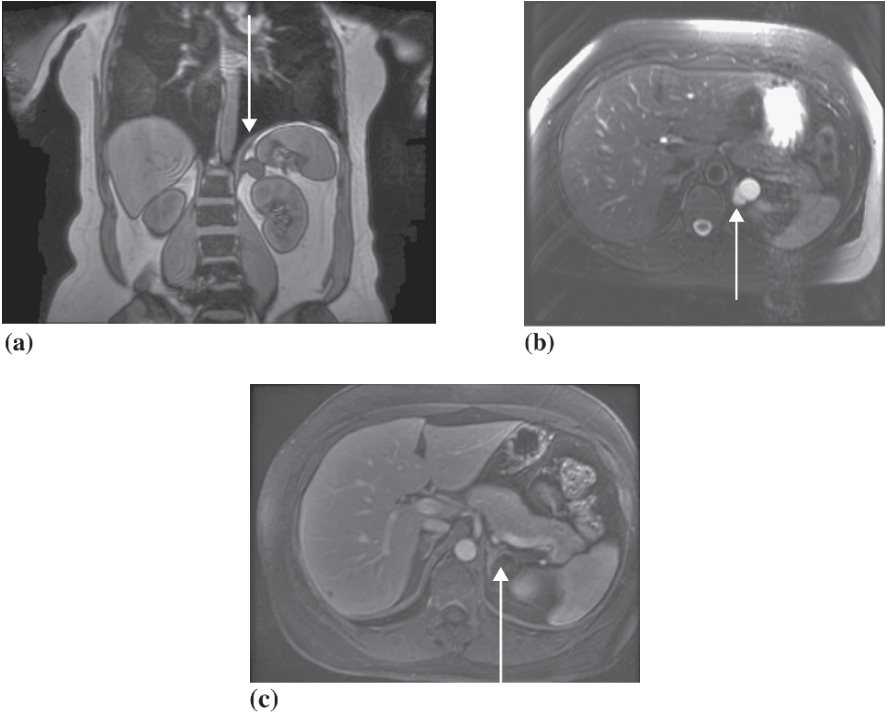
Left adrenal cyst. Coronal T1-weighted (a), axial T2-weighted (b) and gadolinium-enhanced (c) MR images demonstrating a T1 hypointense, T2 hyperintense non-enhancing 2.5 cm left adrenal lesion (arrows) consistent with a cyst
